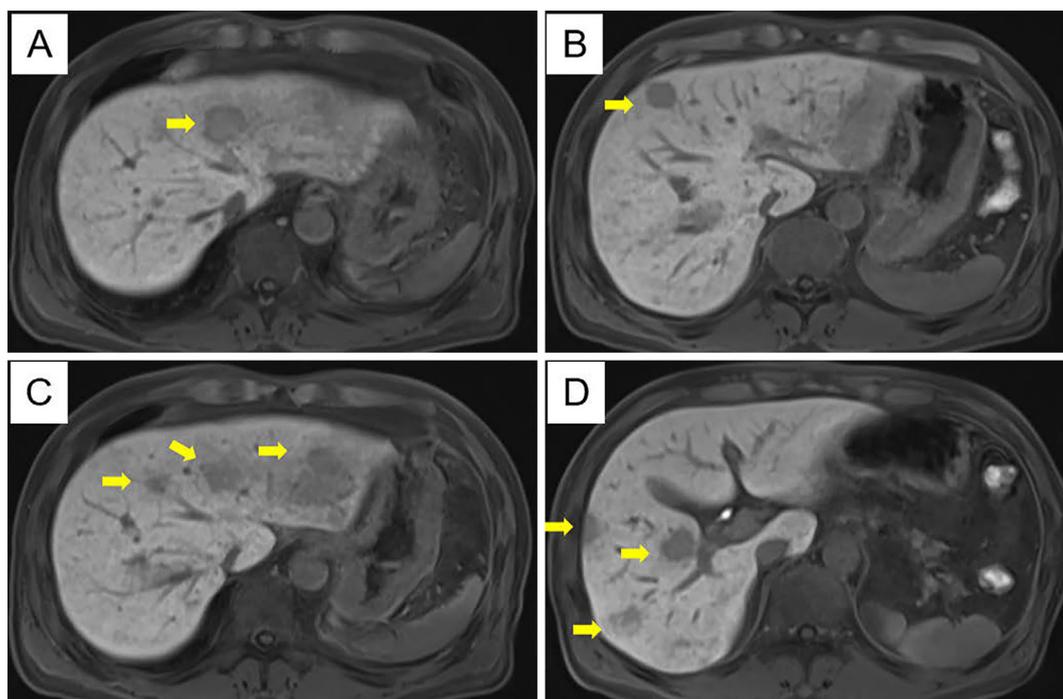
Abdominal MRI findings in the hepatocyte phase. The nodules lack a hepatic uptake of the contrast agent in the hepatocyte phase of a gadolinium-EOB-DTPA contrast study, consisting of well-defined and ill-defined nodules.
